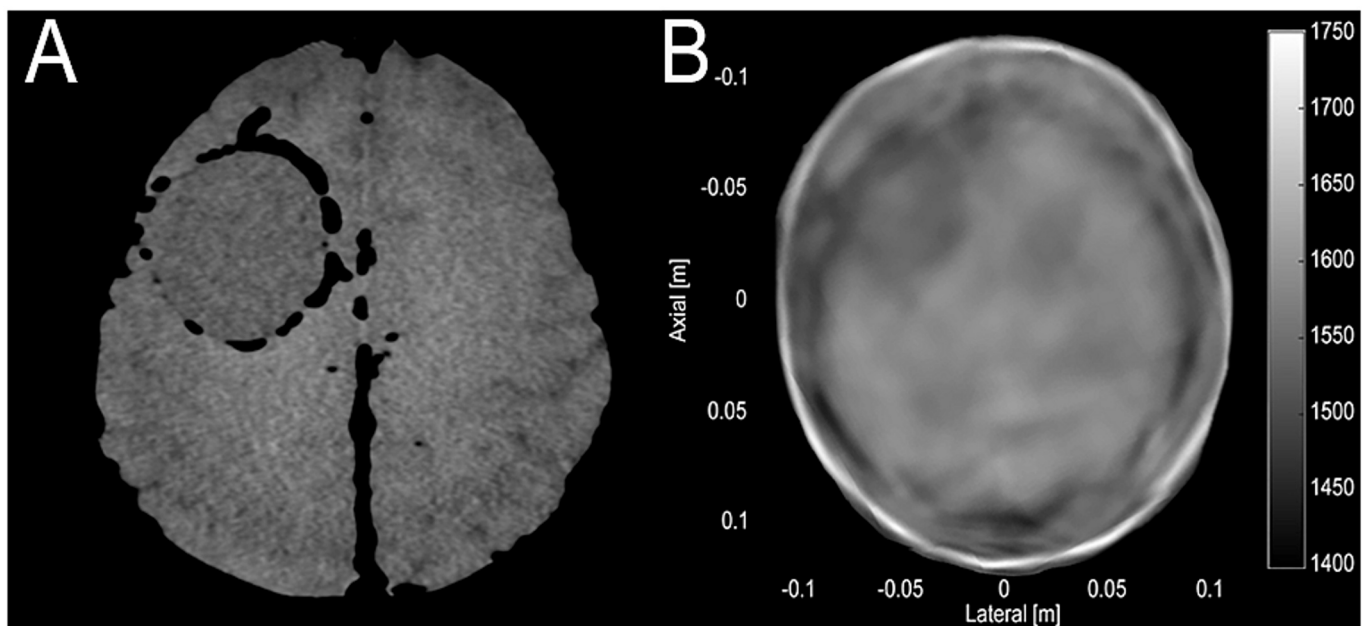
SoftVue Ultrasound Tomographic Imaging of a Brain with a Water-Filled Inclusion Mimicking Hemorrhage Through a Cadaveric Skull. (A) Reference axial CT imaging showing the 40-cc water-filled inclusion mimicking hemorrhage in the left centrum semiovale anteriorly. (B) Axial sound speed ultrasound tomographic image of the skull showing the inclusion in the left centrum semiovale anteriorly. The water-filled inclusion appears dark relative to the background brain parenchyma.
